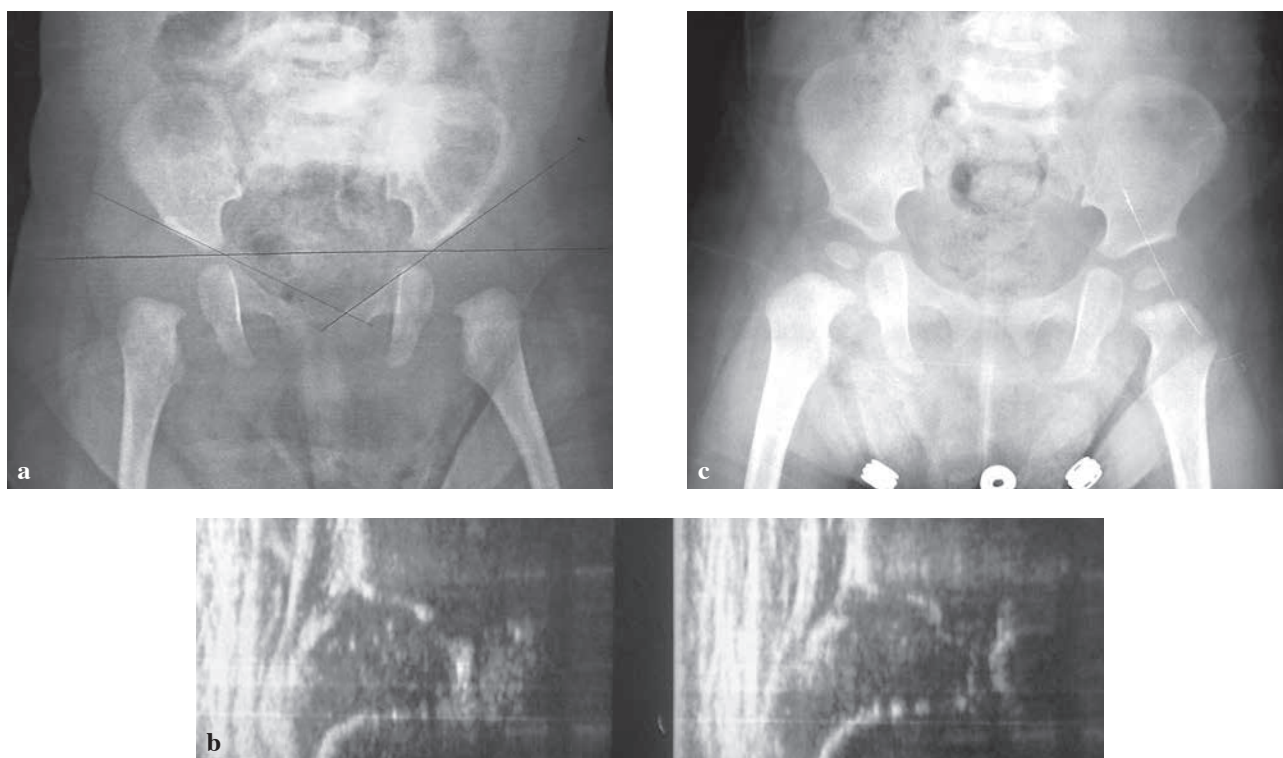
Female infant. (a) Radiograph taken at age 14 weeks ; evaluated as bilateral DDH. (b) Ultrasonography performed one week after the radiograph in 1a shows Graf type 1 (normal) development. (c) Follow-up radiograph obtained at age 11 months shows normal development.
